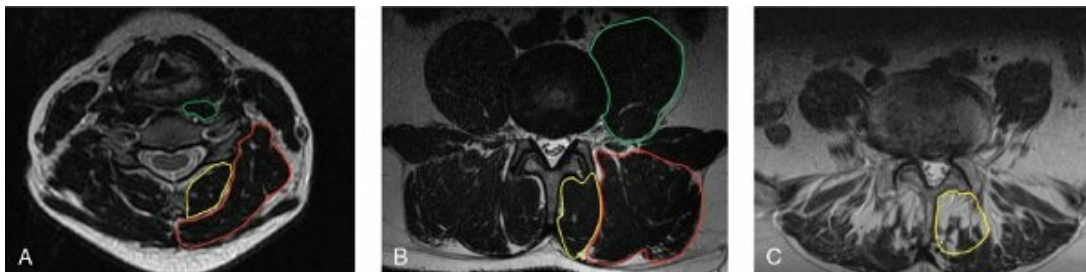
Axial T2-weighted magnetic resonance images of normal midcervical spine muscular. A, The anterior flexor longus collicis (green), the deep extensors semispinalis cervicis and multifidus muscle (yellow), and the superficial extensors semispinalis capitis, splenius capitis, and longissimus muscles (red). B, Normal lumbar spine musculature at the L4-L5 disk space demonstrating the psoas muscle (green), the deep extensor multifidus muscle (yellow), and superficial erector spinae muscle (red). C, Lumbar spine musculature after open decompression shows substantial fatty atrophy of the multifidus muscle (yellow).
